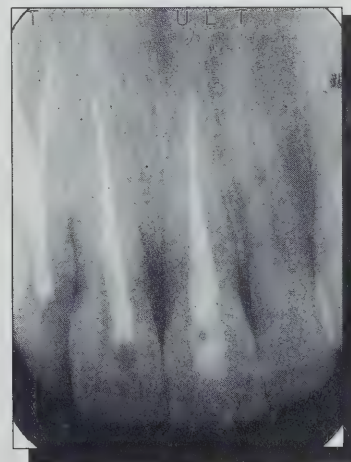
Periapical radiographs of maxillary incisor region at five year recall — January 28, 1992.
